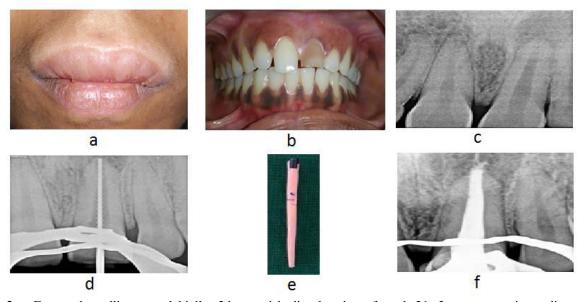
a-Extraoral swelling seen labially, 2.b- greyish discoloration of tooth 21; 2.c- preoperative radiograph; 2.d-working length radiograph, 2.e- customized guttapercha cones; 2.f- obturation radiograph.
